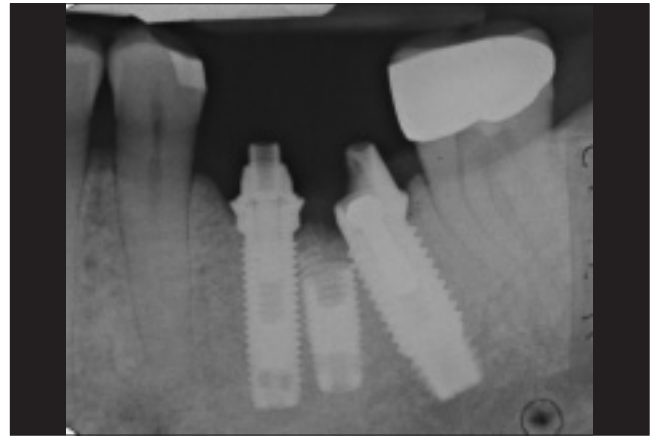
Periapical radiograph of tissue-integrated prosthesis taken at time of delivery.
